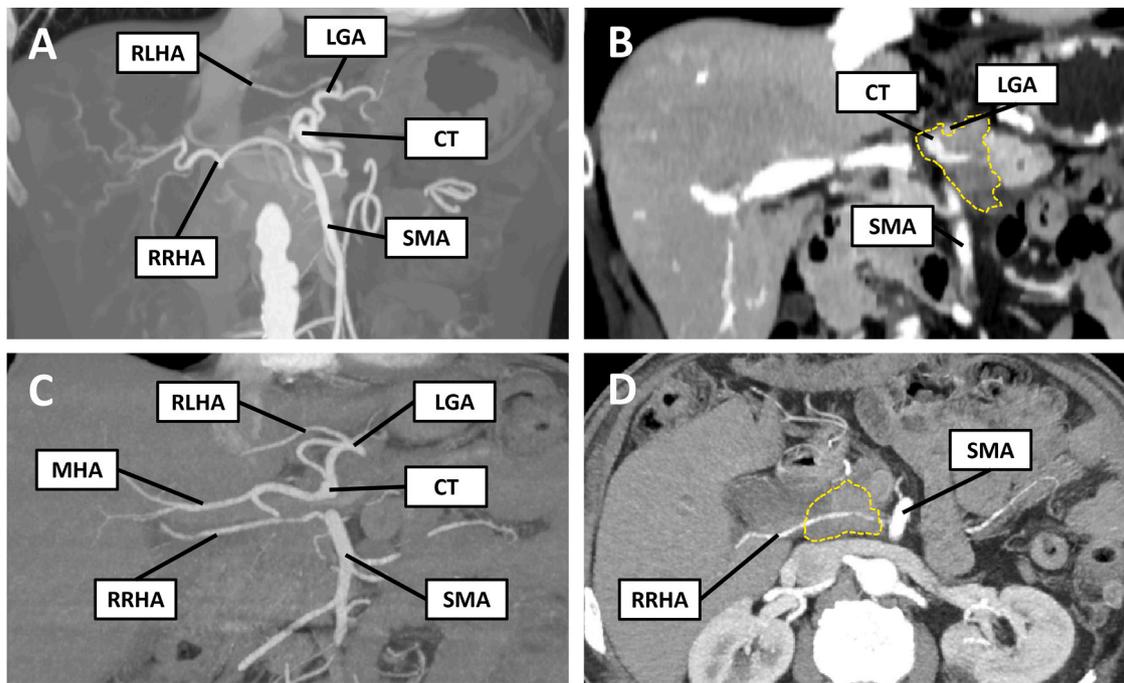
Arterial variants with surgical implications. (A) depicts the anatomy of a patient with a replaced right hepatic artery (RRHA) originating from the superior mesenteric artery (SMA) and a replaced left hepatic artery (RLHA) originating from the left gastric artery (LGA). The celiac trunk (CT) was encased by the tumor, as represented in (B, dashed line). As arterial collaterals were present between both replaced hepatic arteries, a celiac trunk resection along with tumor resection were performed, and the patient maintained a preserved liver vascularization. (C) represents another patient with the following anatomy: RLHA from LGA, middle hepatic artery (MHA) from CT, and RRHA from SMA. The RRHA was encased by tumor, as shown in (D, dashed line). This allowed tumor resection along with the RRHA, after an embolization procedure for facilitating the development of collaterals.
